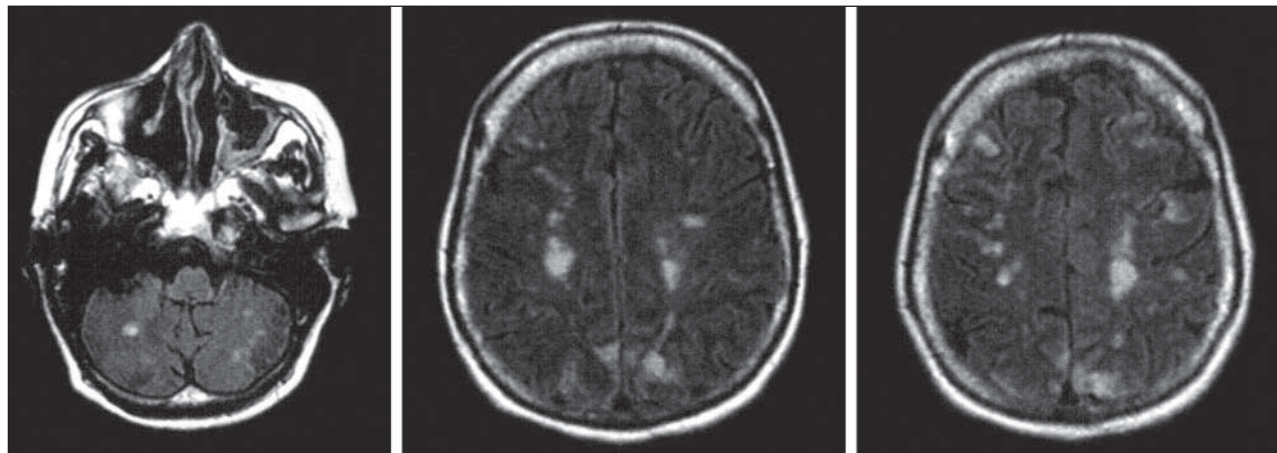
Fluid-attenuated inversion recovery magnetic resonance images demonstrating the patient's partially resolving initial occipital lesions and prominent new cerebral and cerebellar white matter lesions in watershed distribution.
